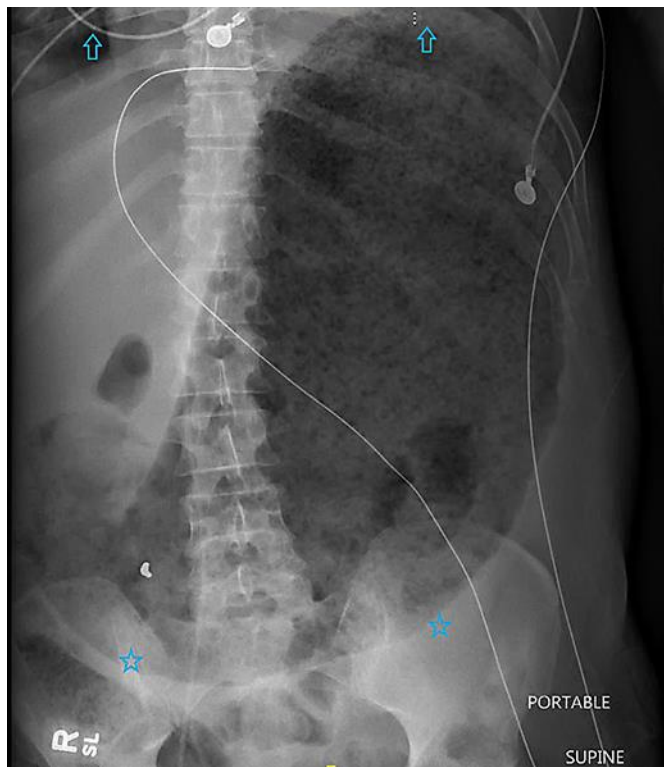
Supine abdominal X-ray demonstrating a massively distended stomach, occupying the length of the abdomen, from the diaphragm (arrows) to the pelvis (asterisks).
